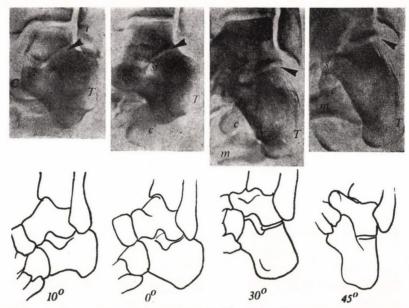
Oblique view roentgenograms of a healthy foot. C: caput tali, s: sustentaculum tali, m: base of the 5th metatarsus, T: tuber calcanei. The arrows show the subtalar joint. Each picture represents the sustentaculum tali as well as the tuber calcanei, consequently these roentgenograms provide information on their fractures or dislocations
